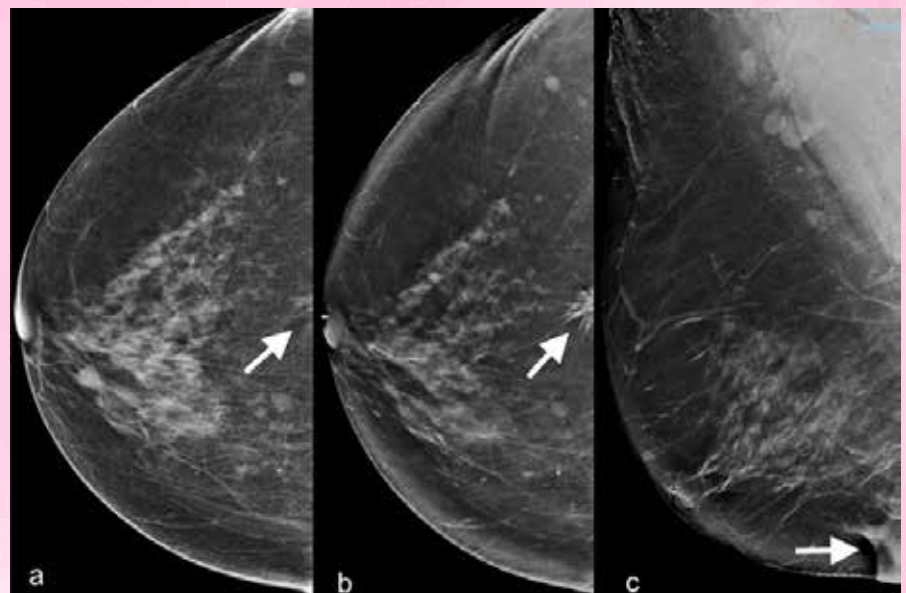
a. CC view showing a near-chest-wall subtle asymmetry (arrow). b. CC view one year later showing an obvious spiculated lesion at same location (arrow). c. Ultrasound confirmed the lesion to be located at 0600; this is not seen due to incomplete depiction of the inframammary fold (arrow).
